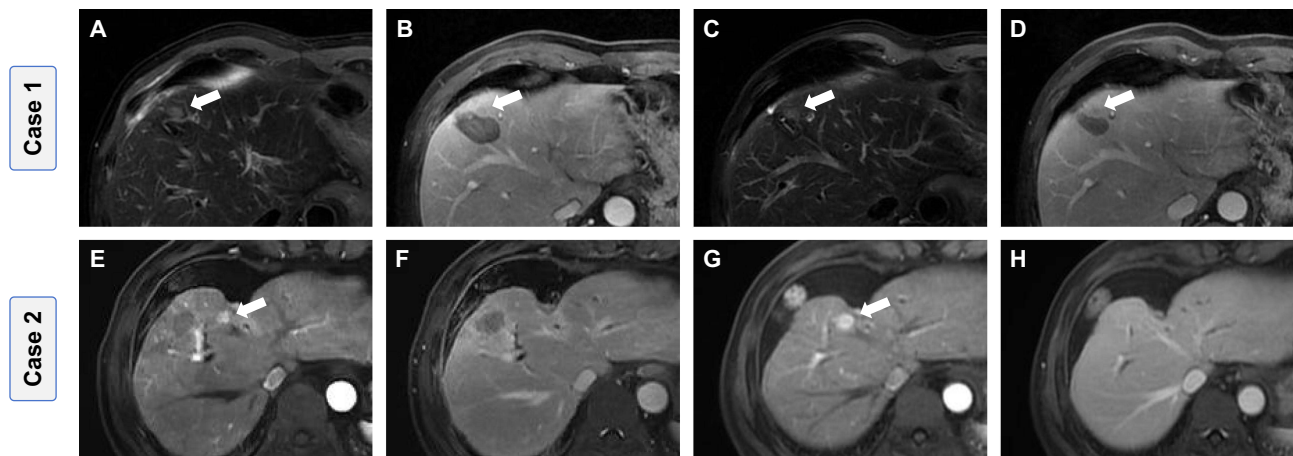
Longitudinal contrast-enhanced MRI of residual and synchronous untreated HCC lesions following MWA. (A–D) A non-rapidly growing residual lesion (TVDT = 66.95 months). Baseline scans obtained 3–5 days post-ablation: (A) T2-weighted imaging and (B) delayed-phase imaging. Follow-up scans at 2.23 months: (C) T2-weighted imaging and (D) delayed-phase imaging. (E–H) A rapidly growing synchronous untreated lesion (TVDT = 0.74 months). Baseline scans obtained 3–5 days post-ablation: (E) late arterial phase and (F) delayed-phase imaging. Follow-up scans at 2.27 months: (G) late arterial phase and (H) delayed-phase imaging. Arrows indicate the lesions used for TVDT assessment.
